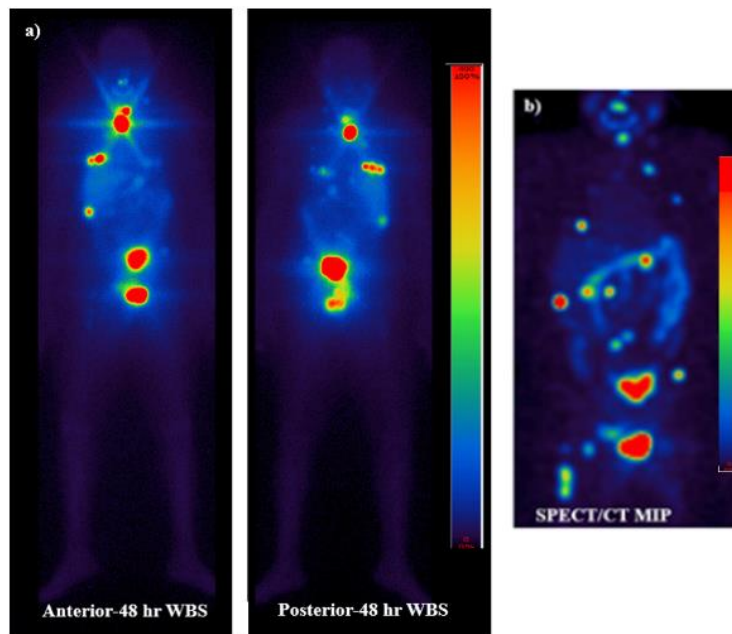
DTC patient Thyca-4 received 7930 MBq of ^{131}I for follow-up (FU) therapy. 48-hour imaging showed good uptake in the thyroid bed, lung, liver, and skeletal metastases. a) WBS and b) SPECT/CT.
